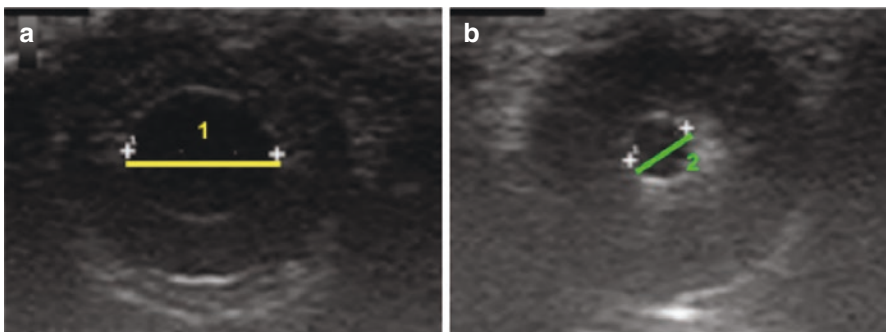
Pupillary B-mode Ultrasound: Pupillary light reflex (PLR); (a) Standard dimmed light conditions and (Yellow line) (1) Measure of pupillary diameter (mm); (b) Ipsilateral Light stimulus, (Green line) (2) Measure of pupillary diameter after light stimulus. (Courtesy: Schmidt et al. [20])
